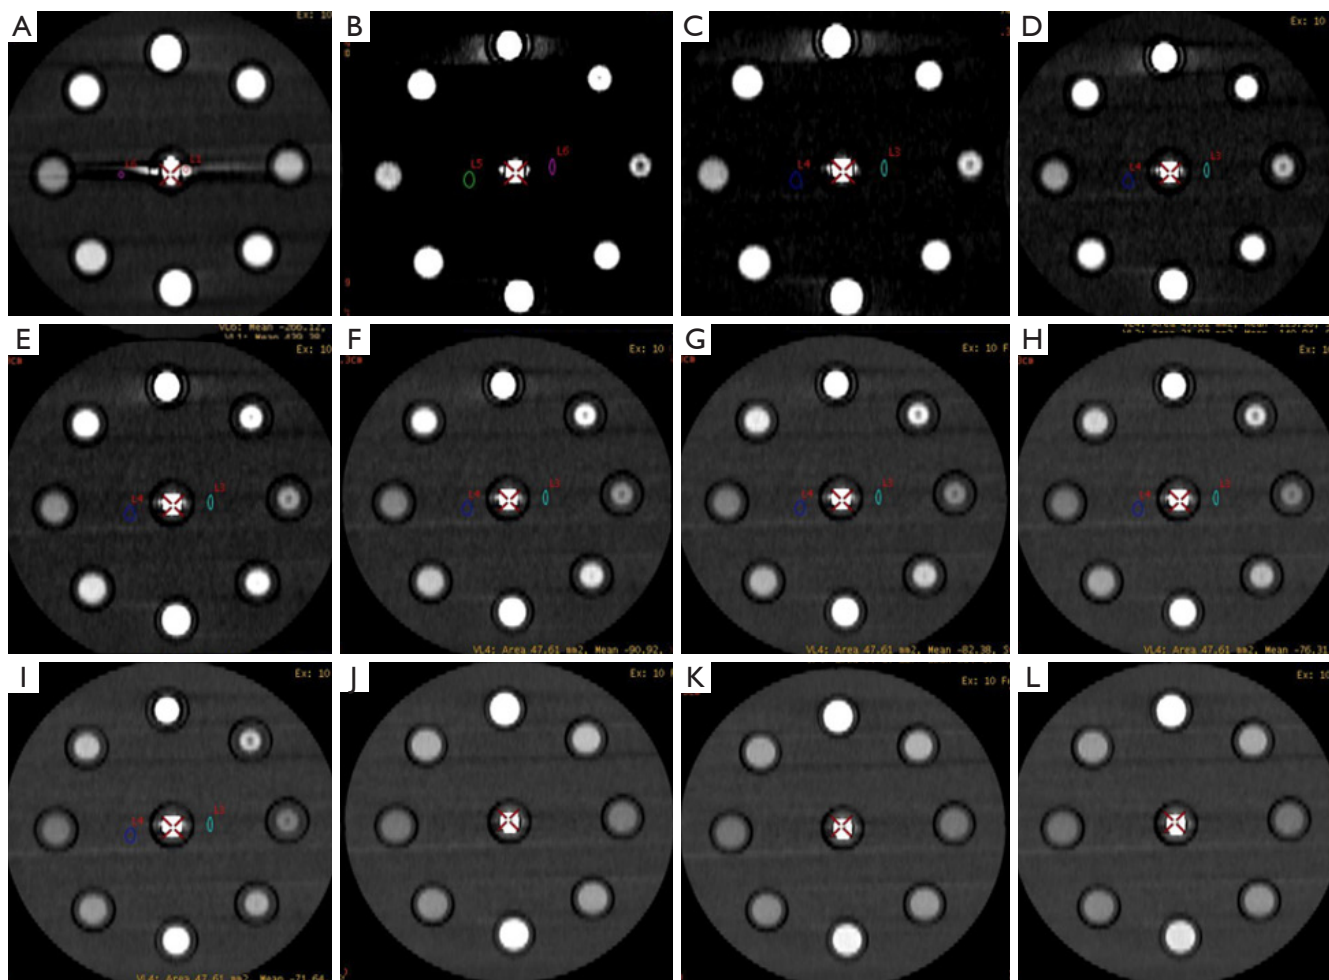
A comparison of high-attenuation artifacts and low-attenuation artifacts between a conventional poly-energy CT image (A) and 40–140 keV MonoE + MARs images (B,C,D,E,F,G,H,I,J,K,L). Both the conventional poly-energy CT image (A) and the 40–140 keV MonoE + MARs images (B,C,D,E,F,G,H,I,J,K,L) showed high- and low-attenuation stripe artifacts produced by the center spring coil, and the artifacts of the 40–140 keV MonoE + MARs images were fewer than those of conventional poly-energy CT images.
